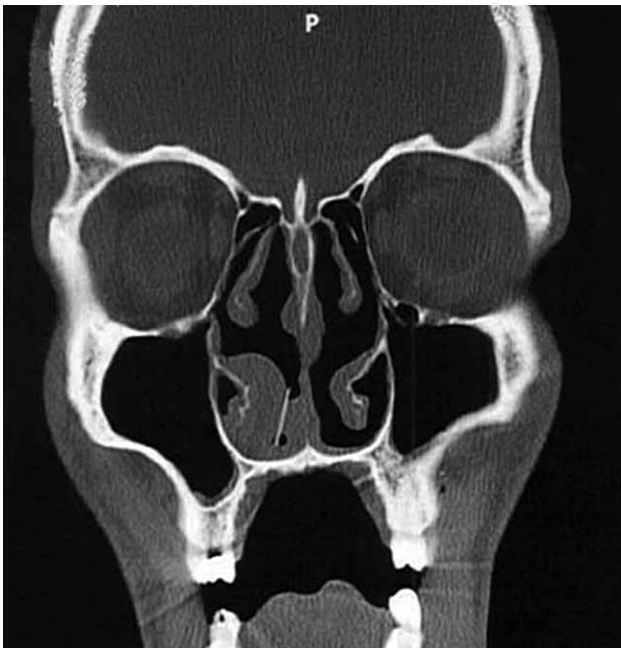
CT image, postoperative appearance, 18 months later.
